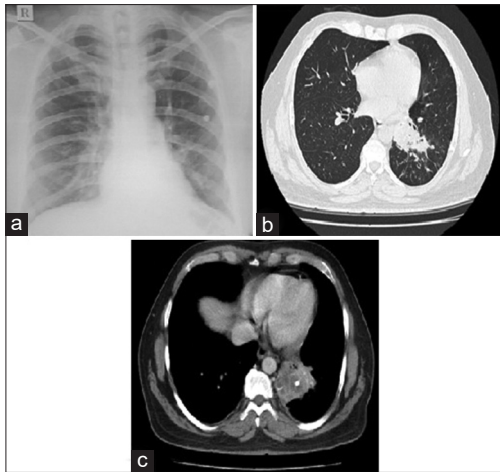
(a) Normal chest X-ray. (b) Chest showing left lower lobe mass with spiculated margins. (c) Endobronchial calcification within the mass invading into the left lower lobe
